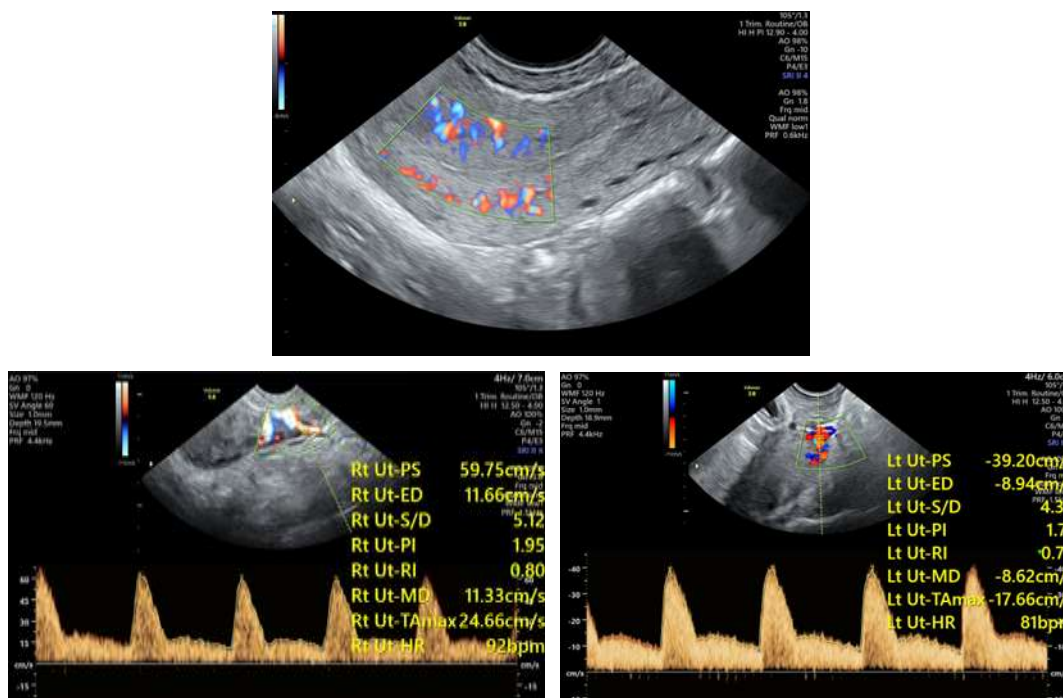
TVS in a 28-year-old woman with recurrent pregnancy loss demonstrating (a) Zone 1 subendometrial vascularity and (b & c) uterine artery Doppler evaluation shows a mean pulsatility index (PI) of 2.6 and mean resistance index (RI) of 0.89.
